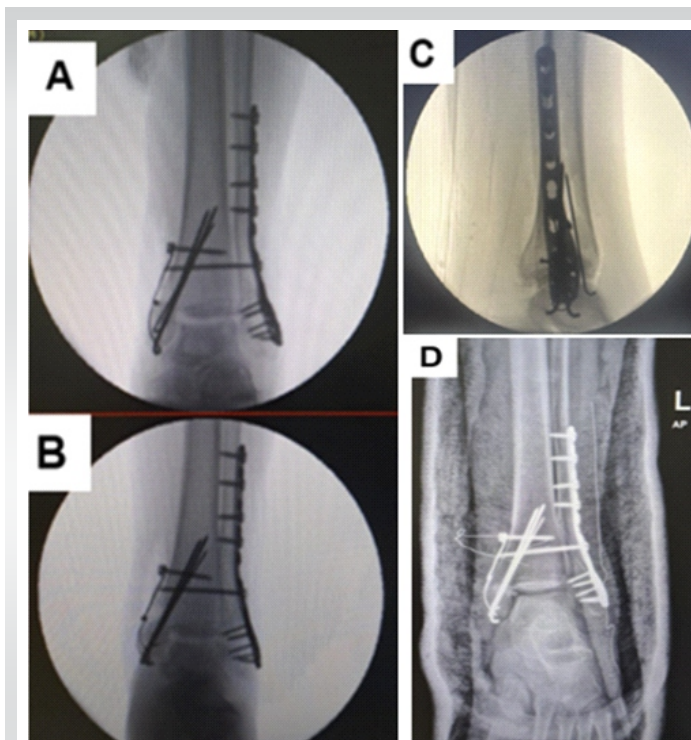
Fluoroscopic images showing initial single 4-cortex syndesmotom screw fixation following open reduction with internal fixation. Mortise (a), Anteroposterior (b), and Lateral (c) views. (d) Post-operative X-ray showing bimalleolar fixation with a single syndesmotom screw in situ.
